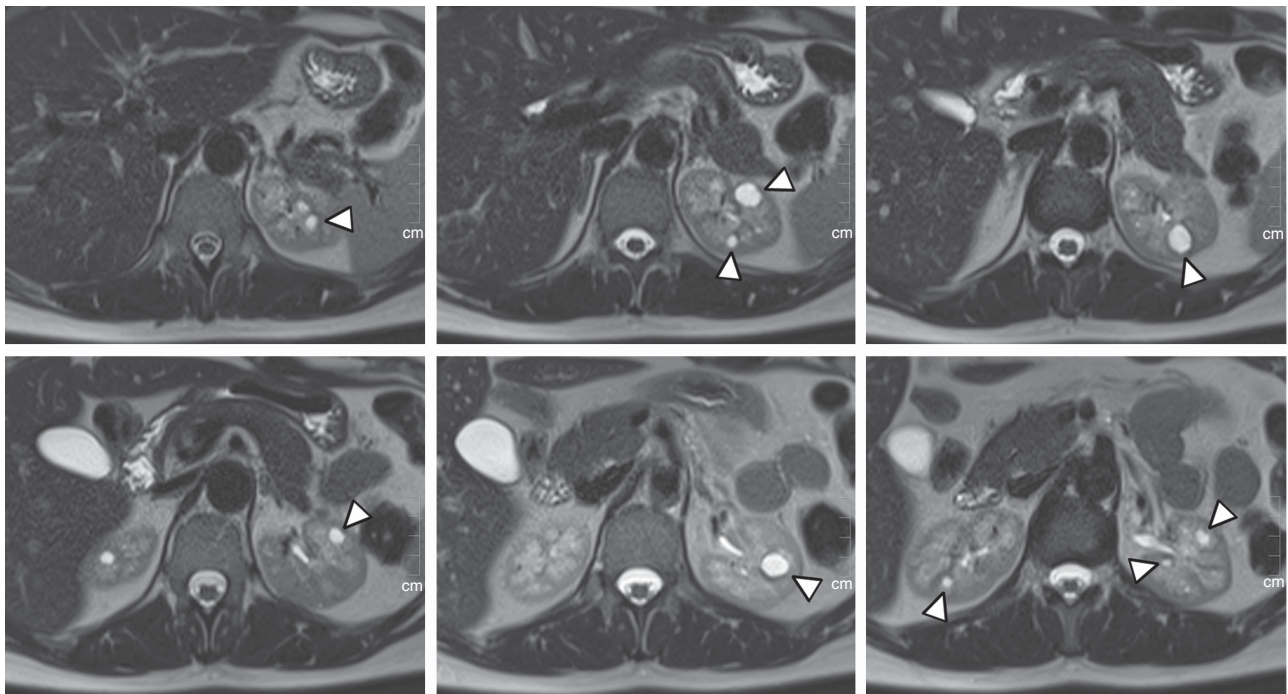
Magnetic resonance imaging (MRI) images of a single affected female with the *MUC1* mutation. T2-weighted axial sections through native kidneys are shown. This female patient (NMW-70, family 10) at 37 years of age has a glomerular filtration rate (GFR) of 51 ml/min and bears the *MUC1* mutation. The number of cysts in this patient is the most pronounced of all patients studied, located either in the parenchyma or at the corticomedullary boundary (indicated by arrowheads).
